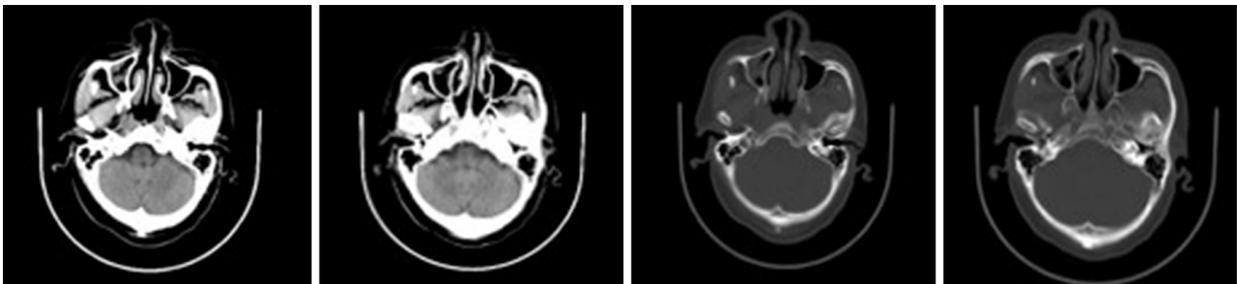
Physical examination (May 31, 2018). Compared to scans obtained on May 26, 2017, an axial head computed tomography scan showed new inflammation in the right maxillary sinus.
